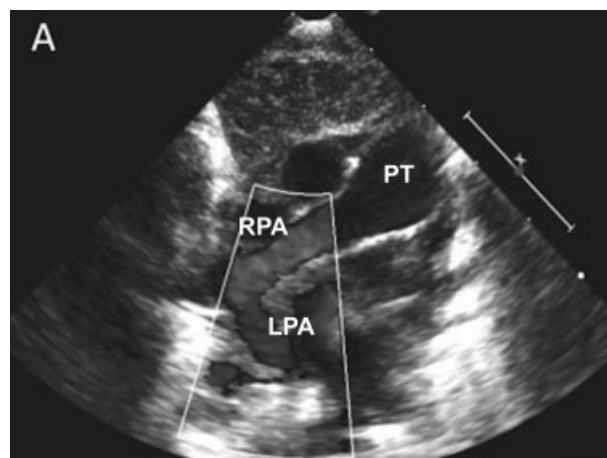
Echocardiograms from Patient 9 : abnormal origin of left pulmonary artery distally from right pulmonary artery can be documented. Abbreviations: LPA, left pulmonary artery; PT, pulmonary trunk; RPA, right pulmonary artery.
